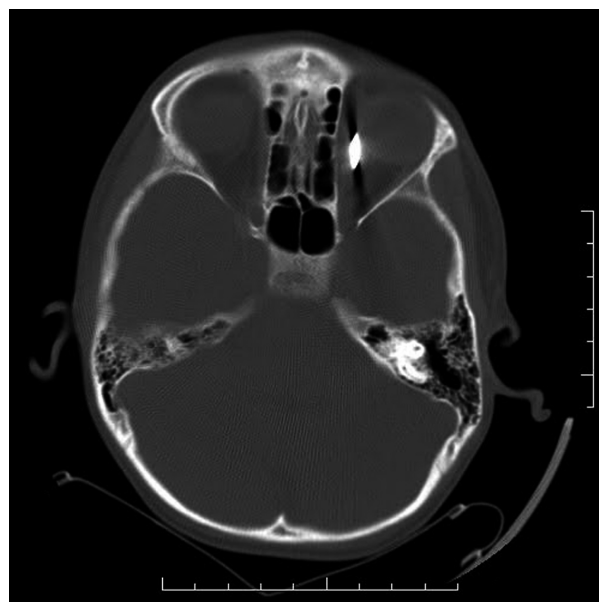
Axial view of CT scan showing metallic foreign body in left orbit.
